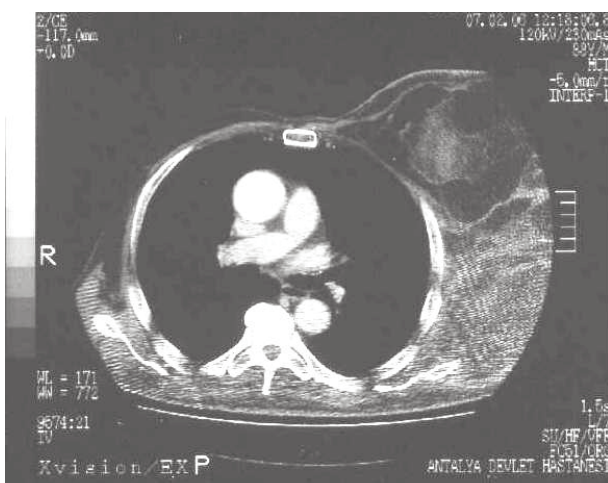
The giant soft tissue mass, which is at the level of the left anterior and lateral thorax wall on CT imaging, and expands to the axillar fossa and breast area.
